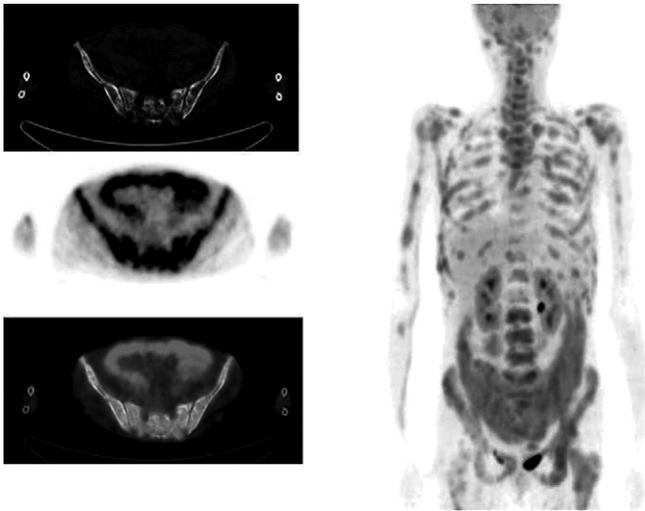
FDG PET/CT after treatment. A clear progression was seen in FDG PET/CT findings comparing to FDG PET/CT imaging before treatment. Multiple nodular masses at the omentum with increased metabolic activity were noticed (Omental cake).
